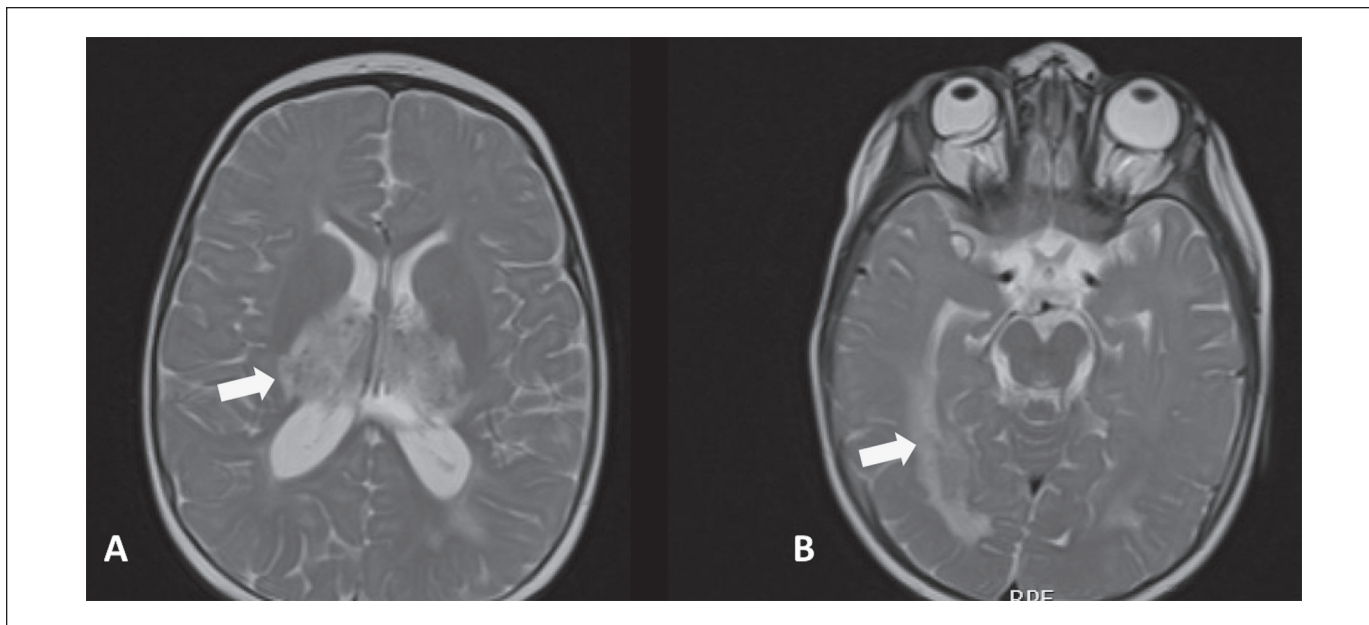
T2-weighted axial magnetic resonance imaging shows (A) bilateral thalamic enlargement with heterogeneous T2 hyperintensity and (B) T2 hyperintensity in the temporo-occipital lobes, greater in the right eye than in the left eye.
